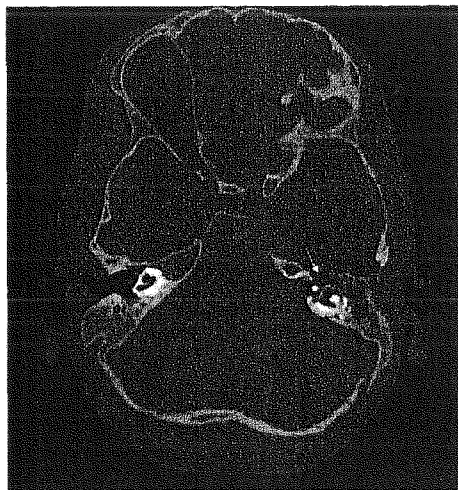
Preoperative axial CT scan, without contrast: abnormal broadening of the labyrinthine part (*asterisk*) of the facial canal on the left side with bony destruction of the middle cranial fossa due to the enlarged geniculate ganglion (*arrow*). The other cells are clouded (CSF).
